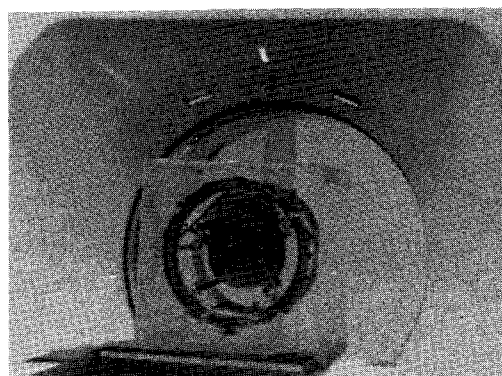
Planning CT with Yeungnam localization device
